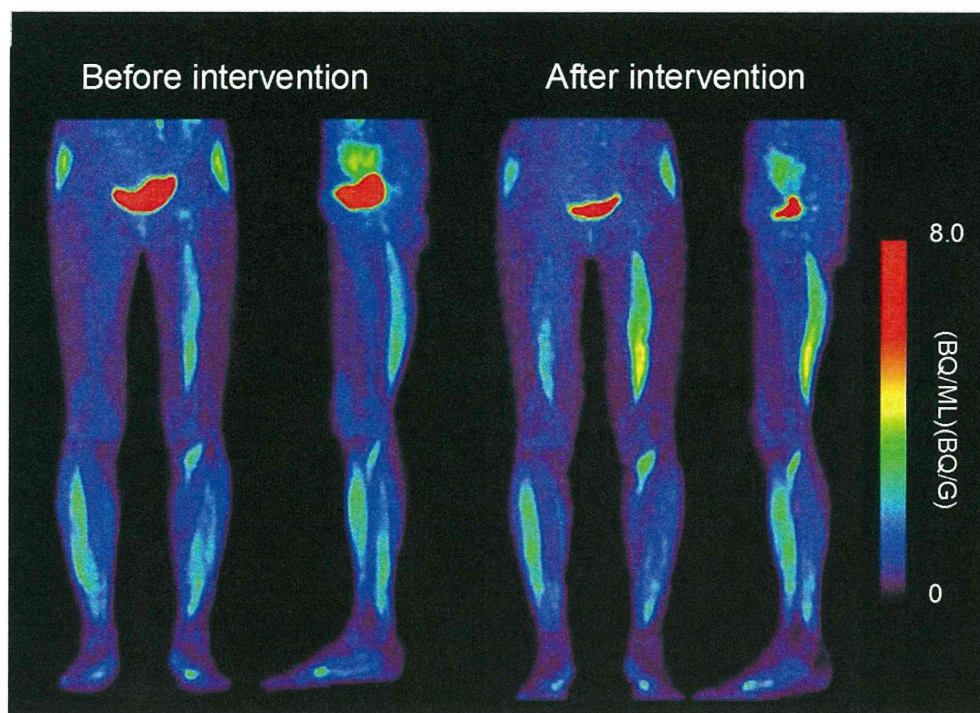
FDG PET images of an older woman before and after the intervention. The left and right panels show before and after intervention images, respectively. FDG uptakes by the gluteus minimus, gluteus medius, rectus femoris and pelvic muscles after the intervention were significantly lower than before.
